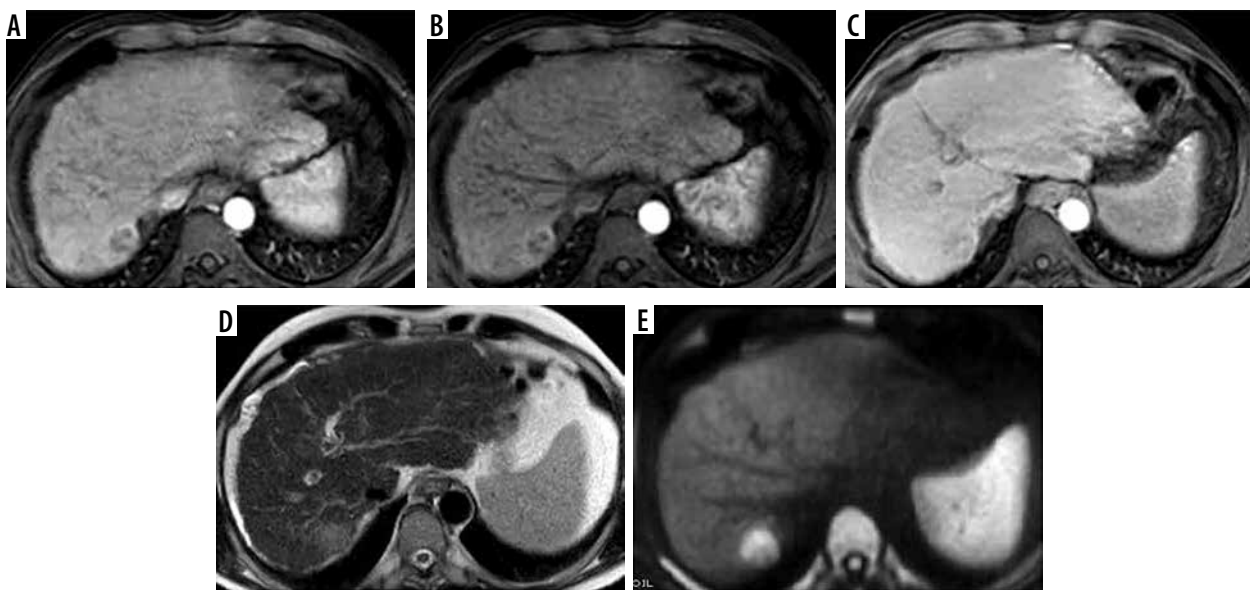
LR-M. A) Arterial phase image shows a hepatic focal lesion with rim arterial hyperenhancement and an enhancing centre. B) The portal venous phase shows no evidence of washout. C) The delayed phase shows no washout of the central enhancing area. D) T2-weighted image shows an intermediate T2 signal. E) Diffusion-weighted imaging shows diffusion restriction
